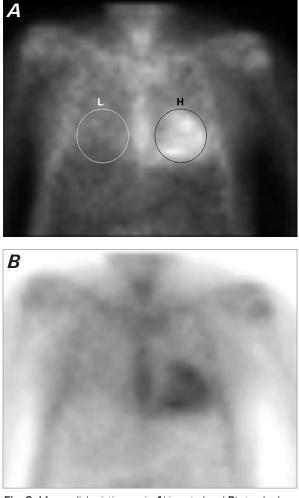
Myocardial scintigrams in A) inverted and B) standard views show substantial cardiac uptake in the heart (H) versus the contralateral lung (L) 1 hour after radiotracer administration, resulting in an H-to-L ratio of 1.52 consistent with transthyretin amyloidosis cardiomyopathy.
